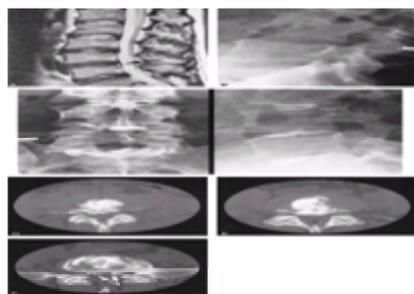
Diskogram. A 34-year-old man with chronic lower back pain with radiation to left leg. A: Sagittal T2-weighted lumbar magnetic resonance imaging examination demonstrates an annular tear at L-4-5 as well as mild disk desiccation at L-3-4 and L-5-S-1. B: Lateral fluoroscopic spot film showing placement of 25-gauge Chiba needles within the intervertebral disks at L-3-4, L-4-5, and L-5-S-1.
